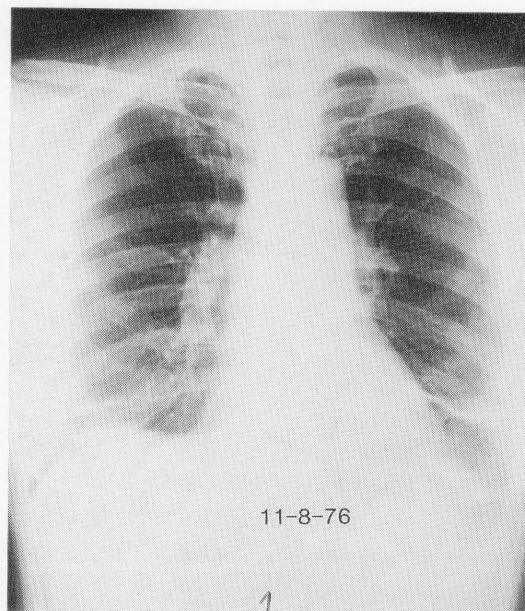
Chest radiograph of a 53 year old female complaining of dyspnea and hemoptysis. Note bilateral basal discoid atelectasis.
